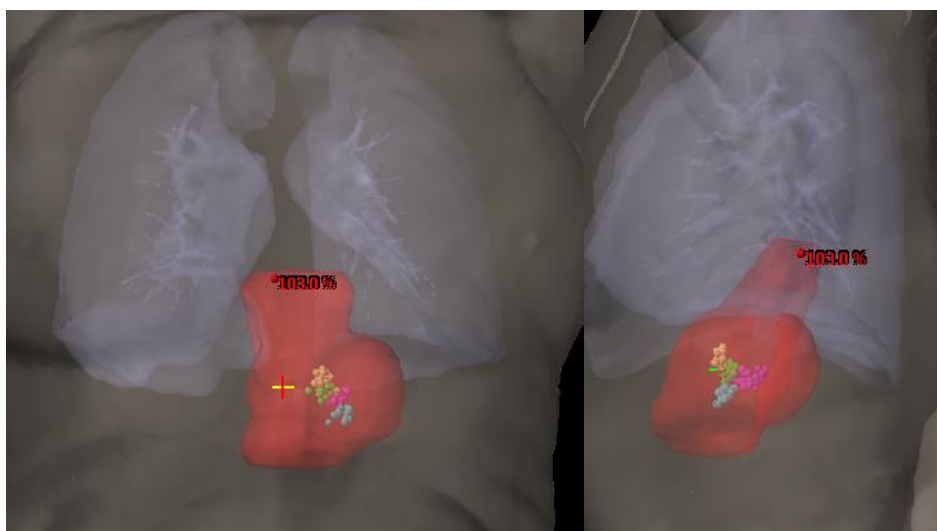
Front and lateral view of patient with the bulbous structures from all CBCT projected in the planning CT.
